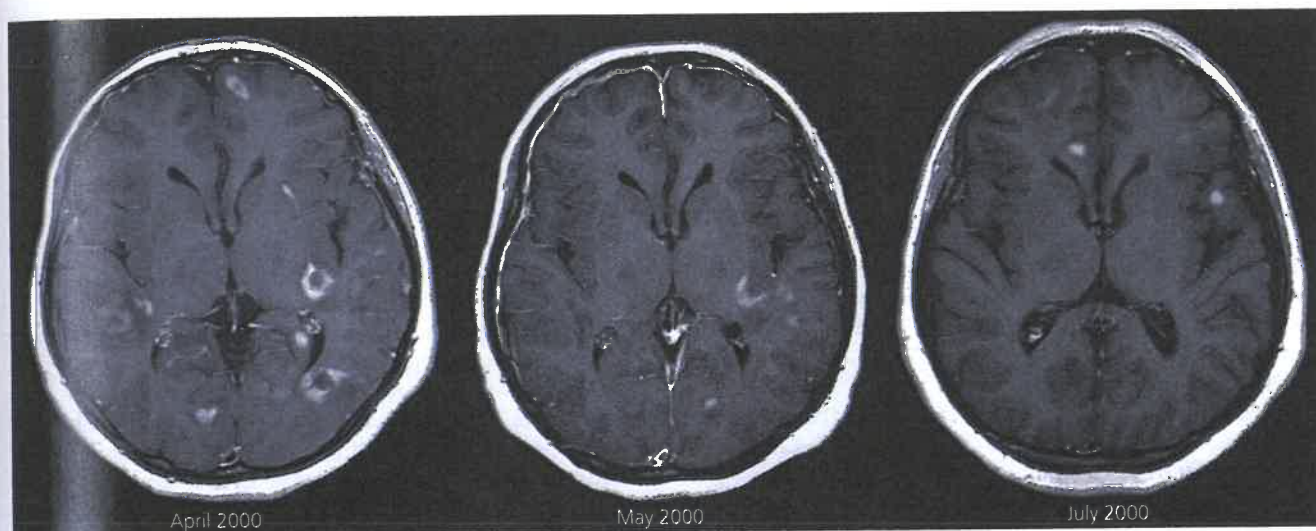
Consecutive gadolinium enhanced brain MRI scans from a patient with relapsing–remitting multiple sclerosis. The MRI activity is high despite clinical quiescence during the study period.
